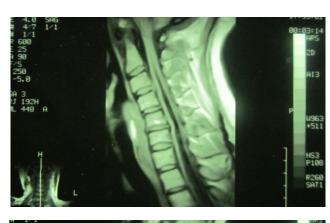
Case 2—cervicothoracic sagittal T_1 - and T_2 -weighted magnetic resonance imaging shows syringohydromyelic cavity extending from cervical region to thoracic region, with type I Arnold-Chiari malformation.
